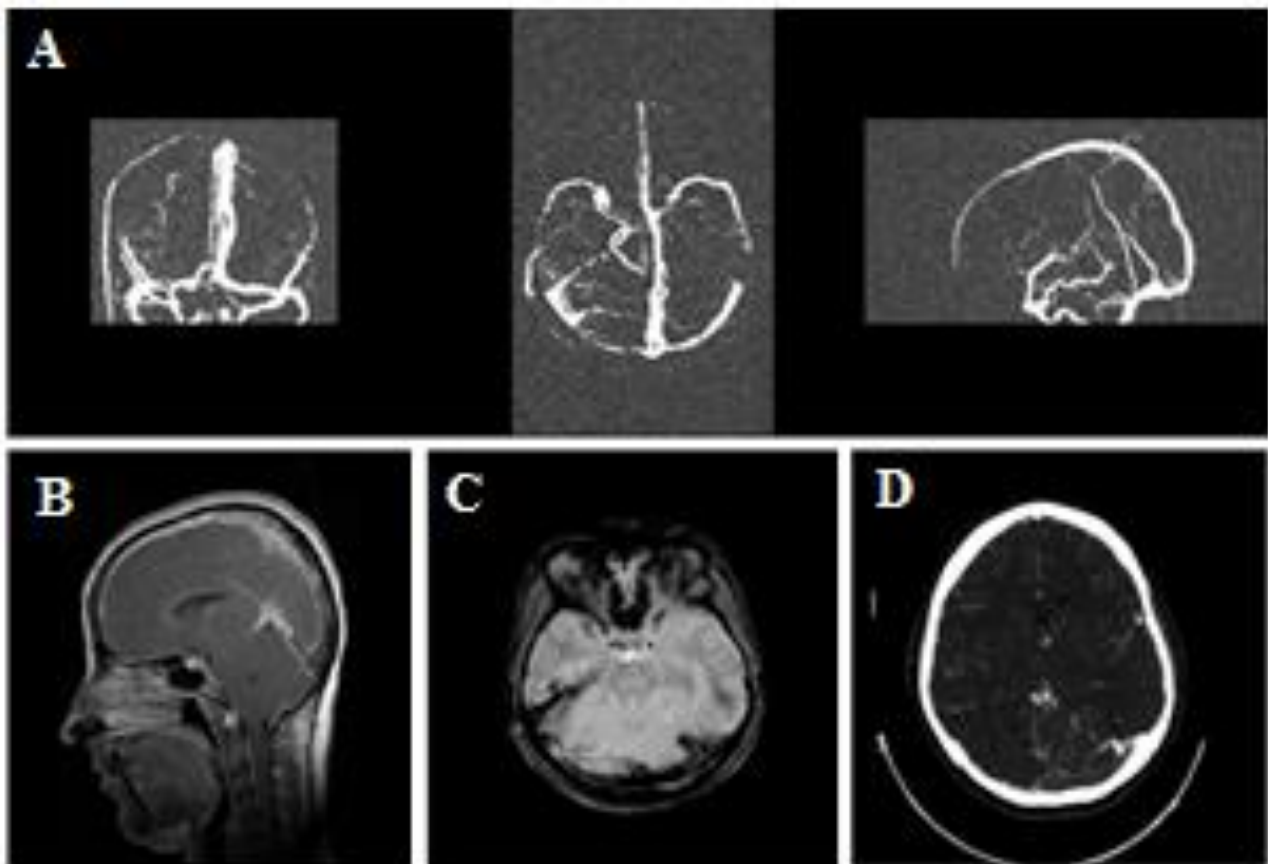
(A) Brain MRV, (B) contrast enhanced MRI, (C) Gradient Echo Image, and (D) CT venography revealed acute venous thrombosis
